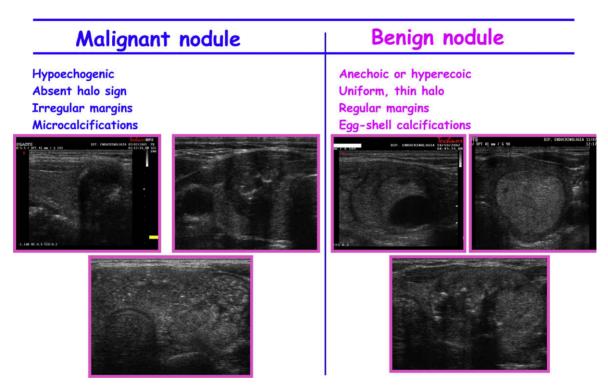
Ultrasound (US) patterns in thyroid nodules.
